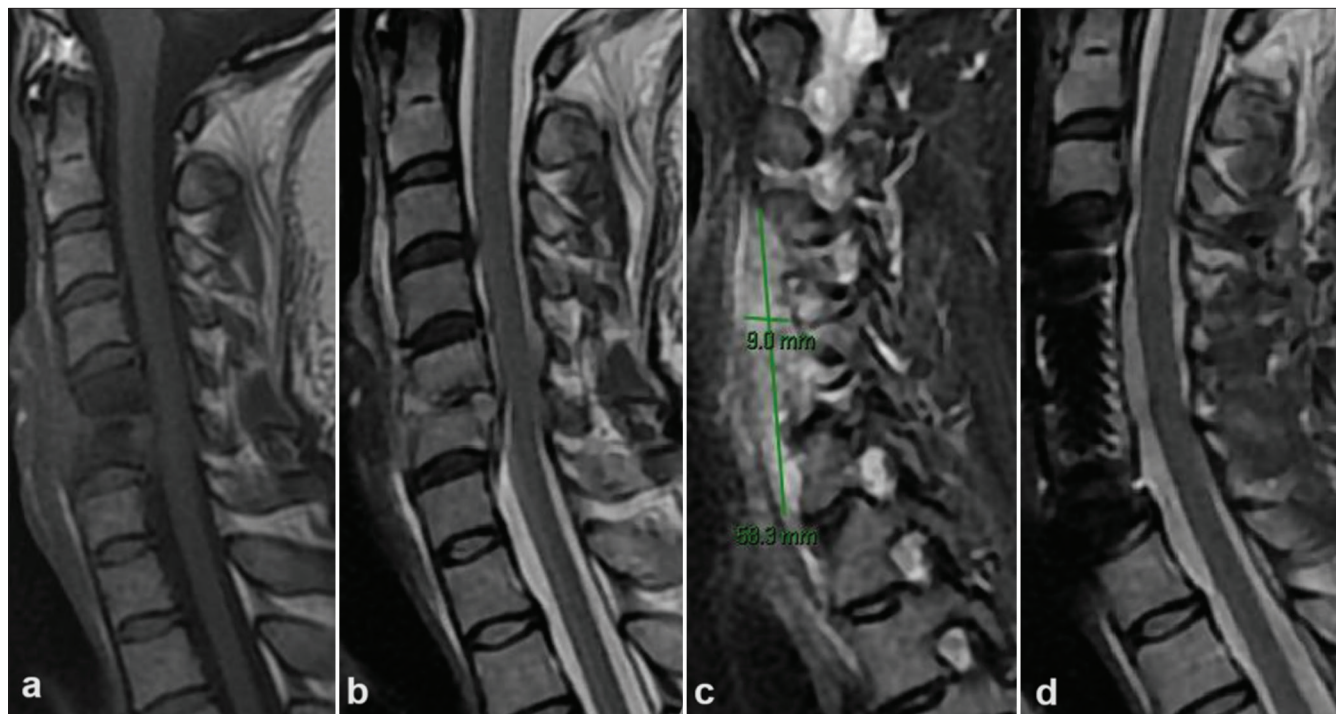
(a-c) Sagittal T1 and T2, and right oblique T2 cervical spine magnetic resonance imaging (MRI). There is decreased T1 and increased T2 signal at the C5-C6 vertebral bodies with a high T2 signal in the disc in between. The disc space is narrowed. The vertebral end plates are irregular and ill-defined. There is a paravertebral abscess extending from C3 to C7. All this corresponds with spondylodiscitis of C5-C6 with moderate spinal stenosis. The green lines mark a paravertebral abscess extending from C3 to C7 that measures 9.0 x 58.3 mm. (d) T2 MRI sequence showing post C5 and C6 corpectomy plus anterior fixation status with improved spinal stenosis, spondylodiscitis, and abscess.
